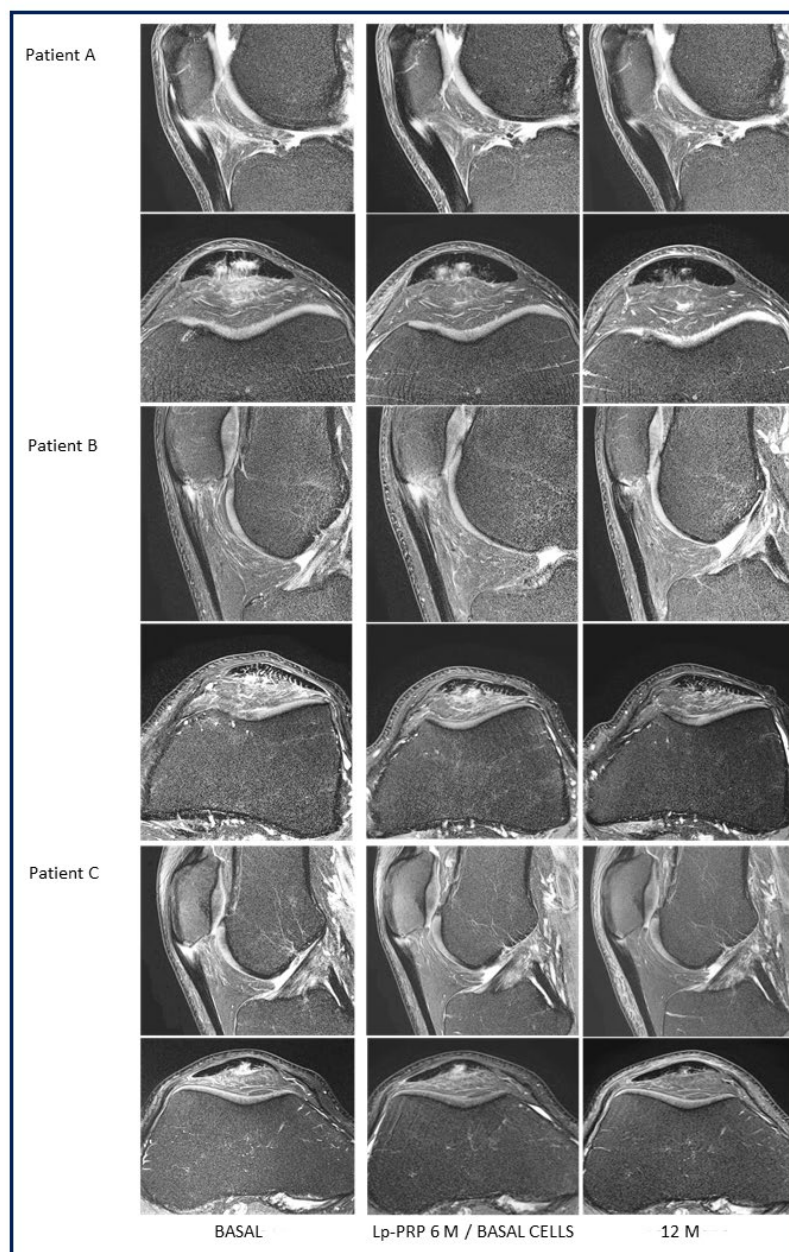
Sagittal (top row) and axial (bottom row) T2-weighted fat-saturated magnetic resonance imaging sequences of 3 patients who were initially treated with leukocyte-poor platelet-rich plasma (Lp-PRP) and then with bone marrow–derived mesenchymal stem cells (BM-MSCs). Shown are images from baseline, the 6-month follow-up (after Lp-PRP), and the 12-month follow-up (after BM-MSCs).
